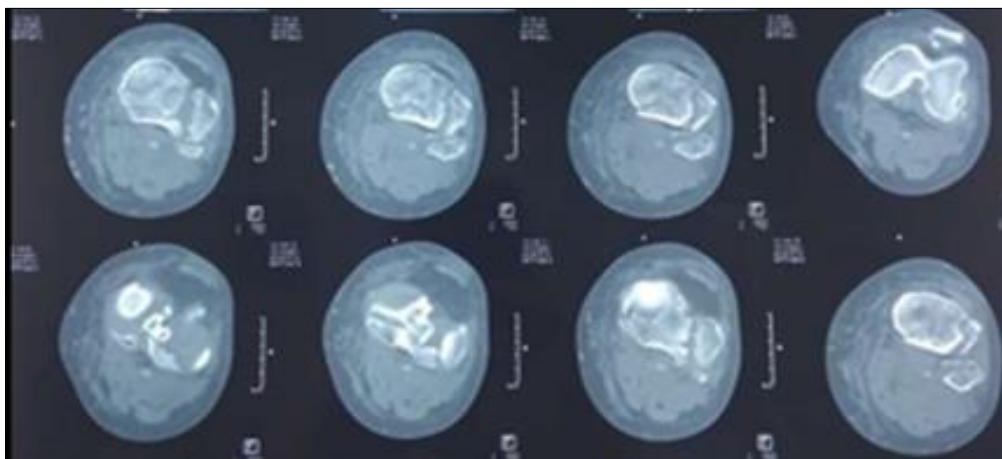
Axial view objectifying posteromedial fragment on CT scan
